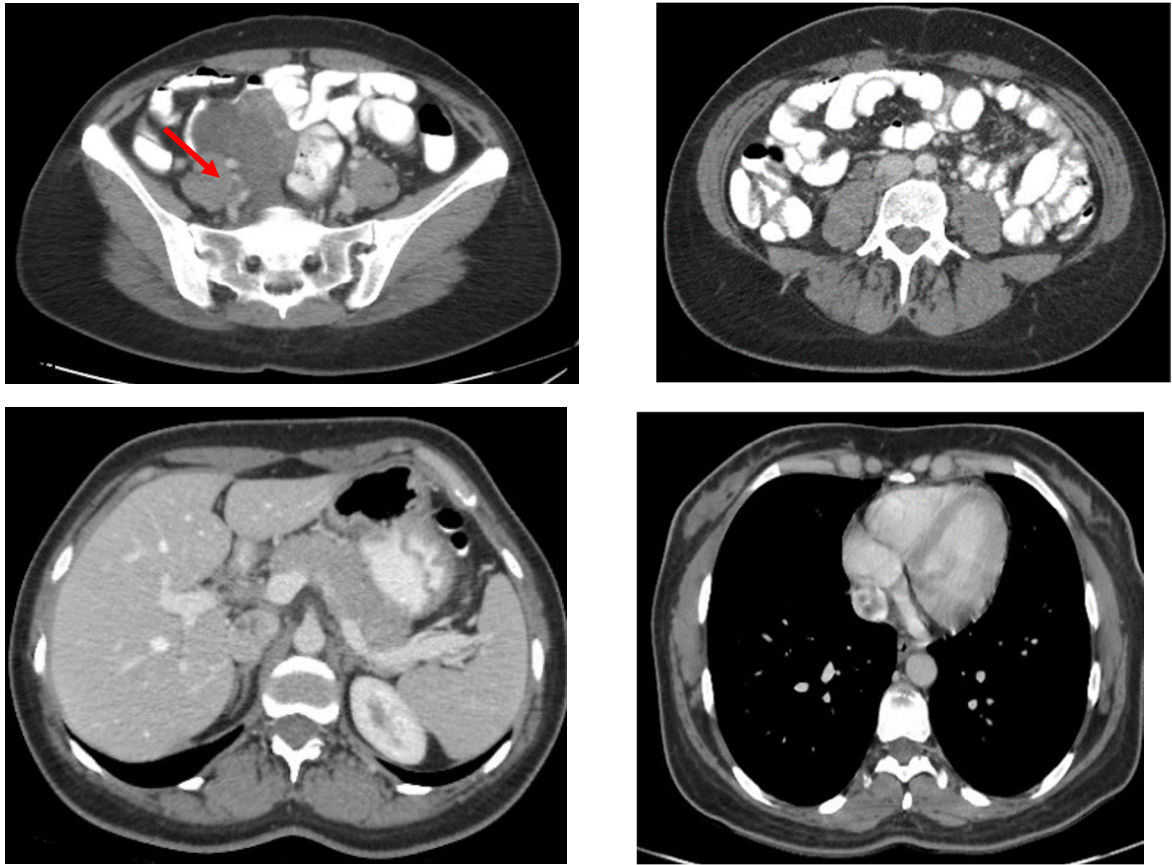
Abdominopelvic CT scan with IV and PO contrast axial images: a) at pelvic level, there is right adnexal cystic lesion. filling defect in right external iliac vein is present (red arrow). b) at distal IVC level, filling defect in IVC is visualized. c) IVC at the level of hepatic vein confluence reveals luminal thrombosis. d) suprahepatic IVC shows luminal filling defect
